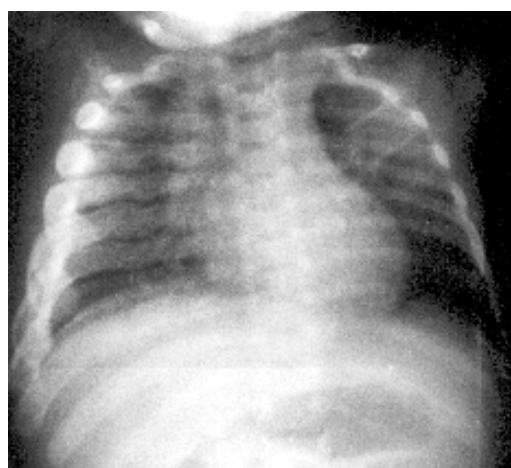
Plain X-ray of the chest (antero-posterior view) showing cortical hyperostosis of the ribs.
